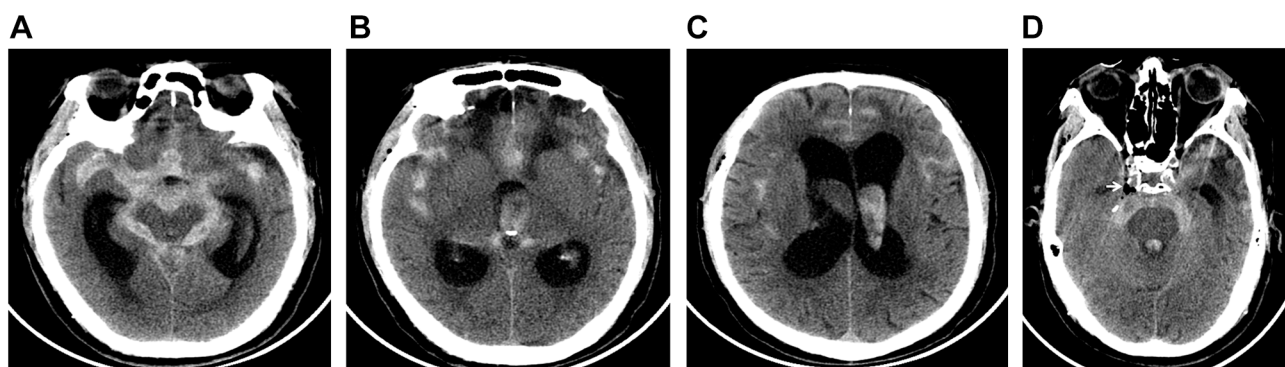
Initial non-enhanced brain CT showing basal SAH.
